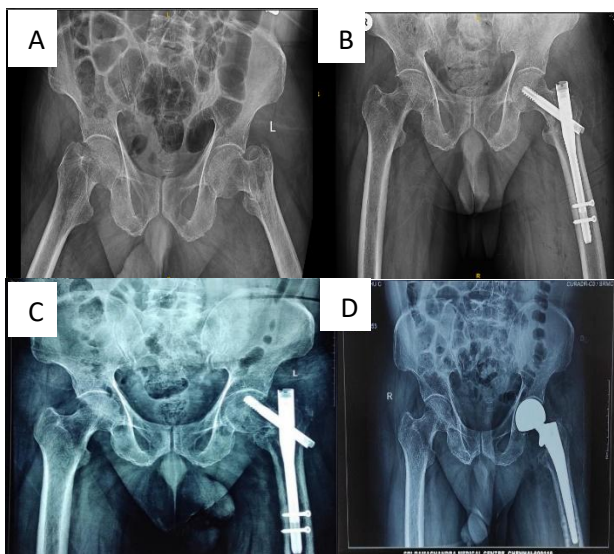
(A) Initial injury; (B) immediate post operative radiograph; (C) X-ray of hip show screw cut through and varus collapse and subsequent implant failure; (D) conversion hemiarthroplasty was done keeping in mind age and acetabular status of patient.
